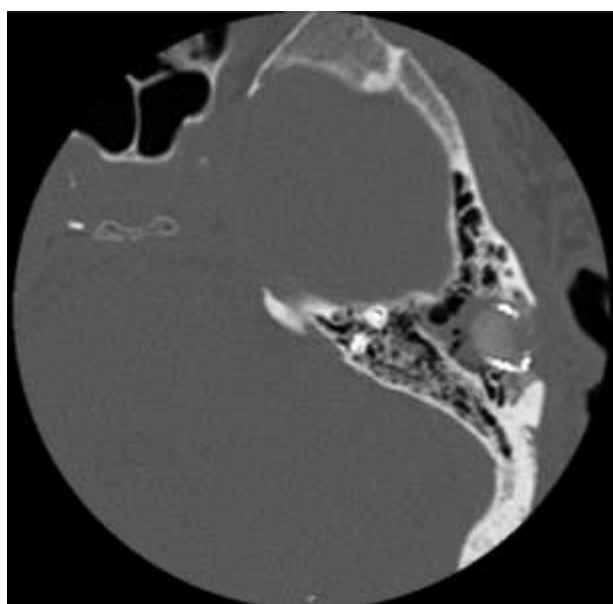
Axial CT-scan showing placement of electrodes in superior semicircular canal.
